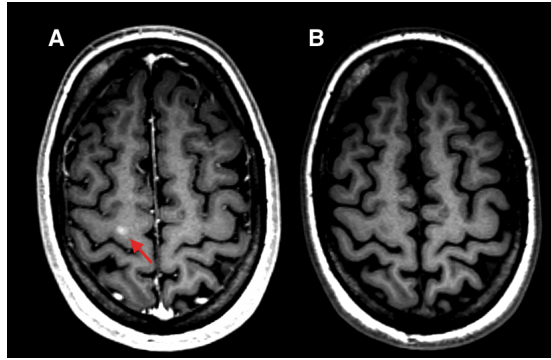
Active lesion (A) appearance in the post-contrast T1-weighted MRI (red arrow), (B) absence in the pre-contrast T1-weighted MRI obtained in a patient with relapsing-remitting multiple sclerosis.
